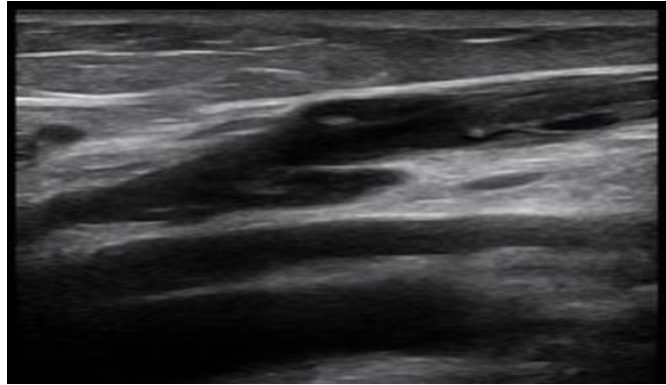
Thrombosis of the saphenous and small saphenous vein on the right side with a doppler.
